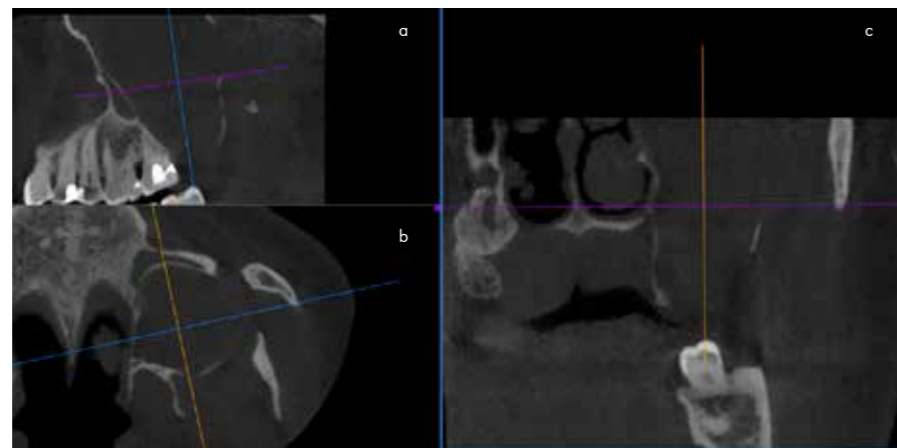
CBCT scan taken on 05/10/2020 showing a) sagittal b) axial c) coronal views of a unilocular lesion within the maxilla and maxillary antrum
